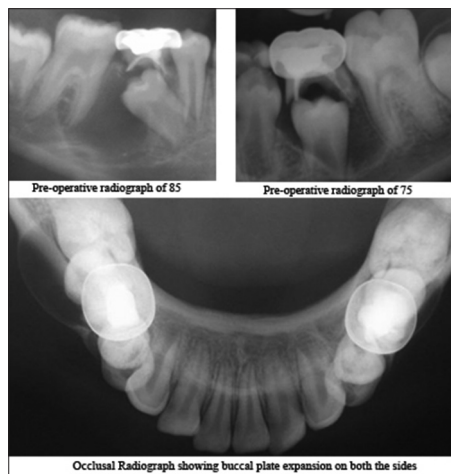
Preoperative intraoral and occlusal radiographs
